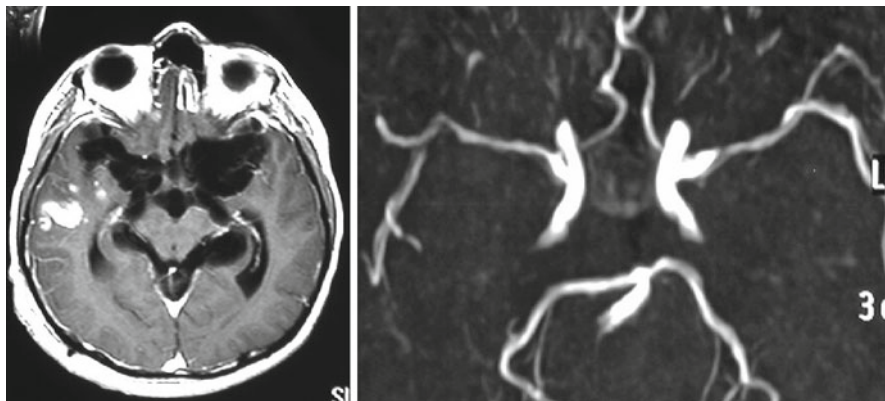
Contrast-enhanced MRI of a patient presenting with an acute stroke syndrome, showing large clumps of cysticerci within the basal subarachnoid cisterns and a recent infarction in the right temporal lobe (*left*) and MRA showing multiple stenosis of major intracranial arteries arising from the circle of Willis (*right*)
